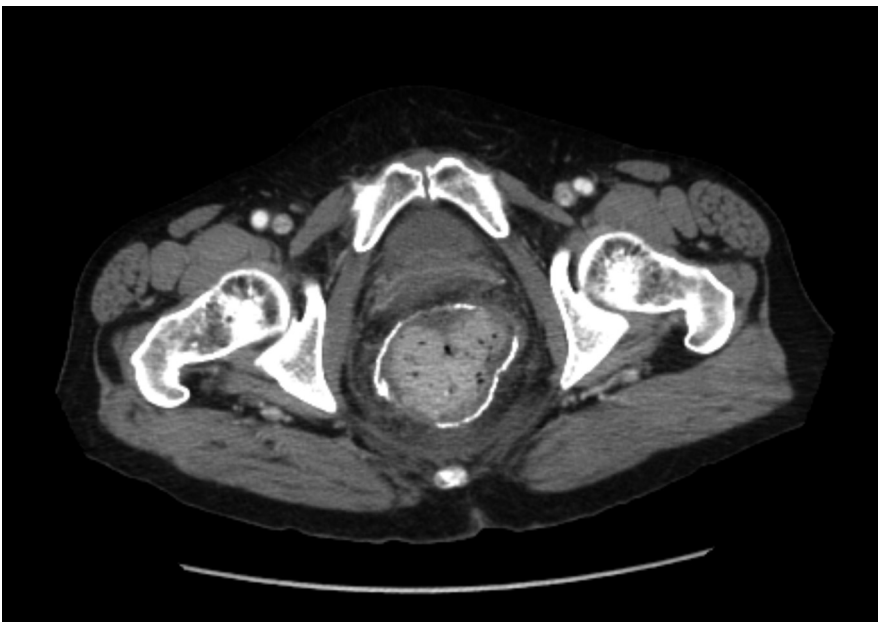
Post-STARR abdominal CT: fecaloma in rectal ampulla.
